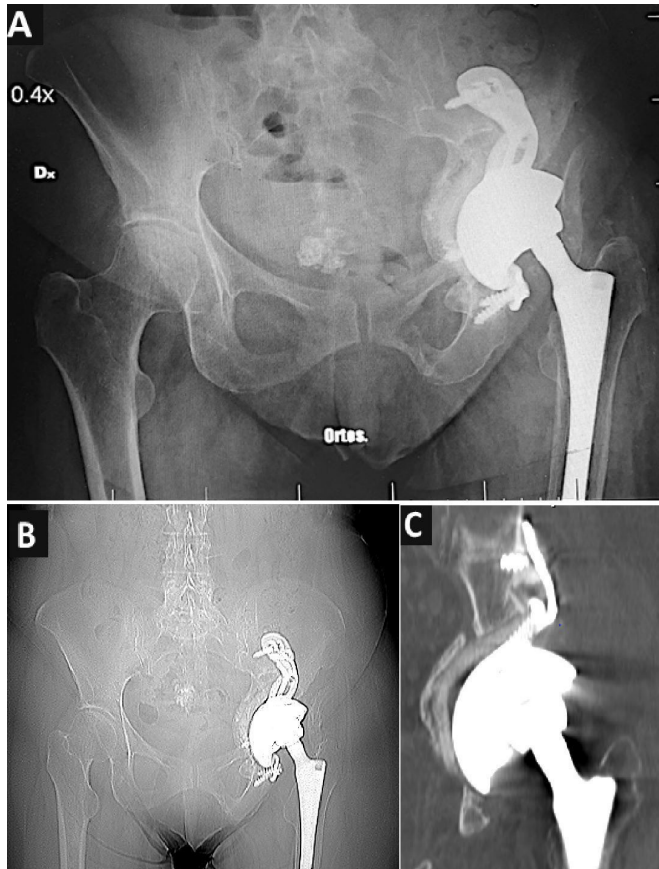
Postoperative X-ray (A) and CT scan (B,C) showed accurate placement of the acetabular component.
